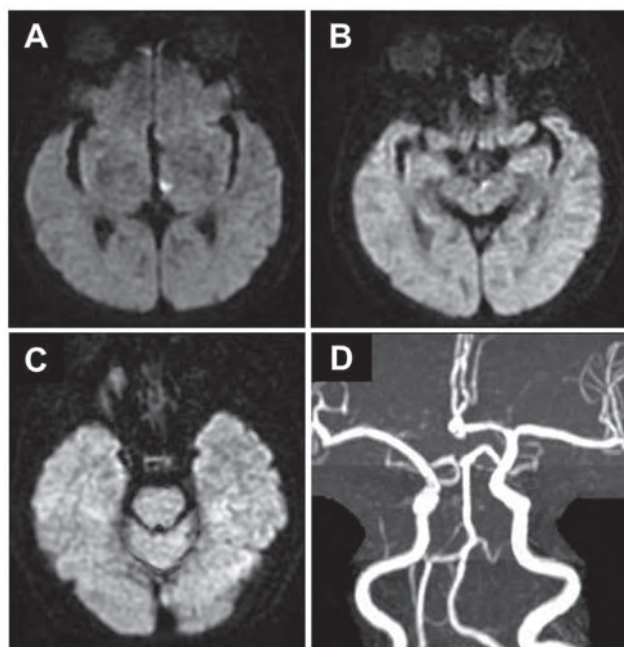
Brain MRI findings of the reported case. There were tiny infarctions at (A) left medial thalamus and (B) left midbrain but (C) without signal change at pons on diffusion-weighted imaging of MRI. (D) MR angiography showed patent vertebral-basilar arteries.
